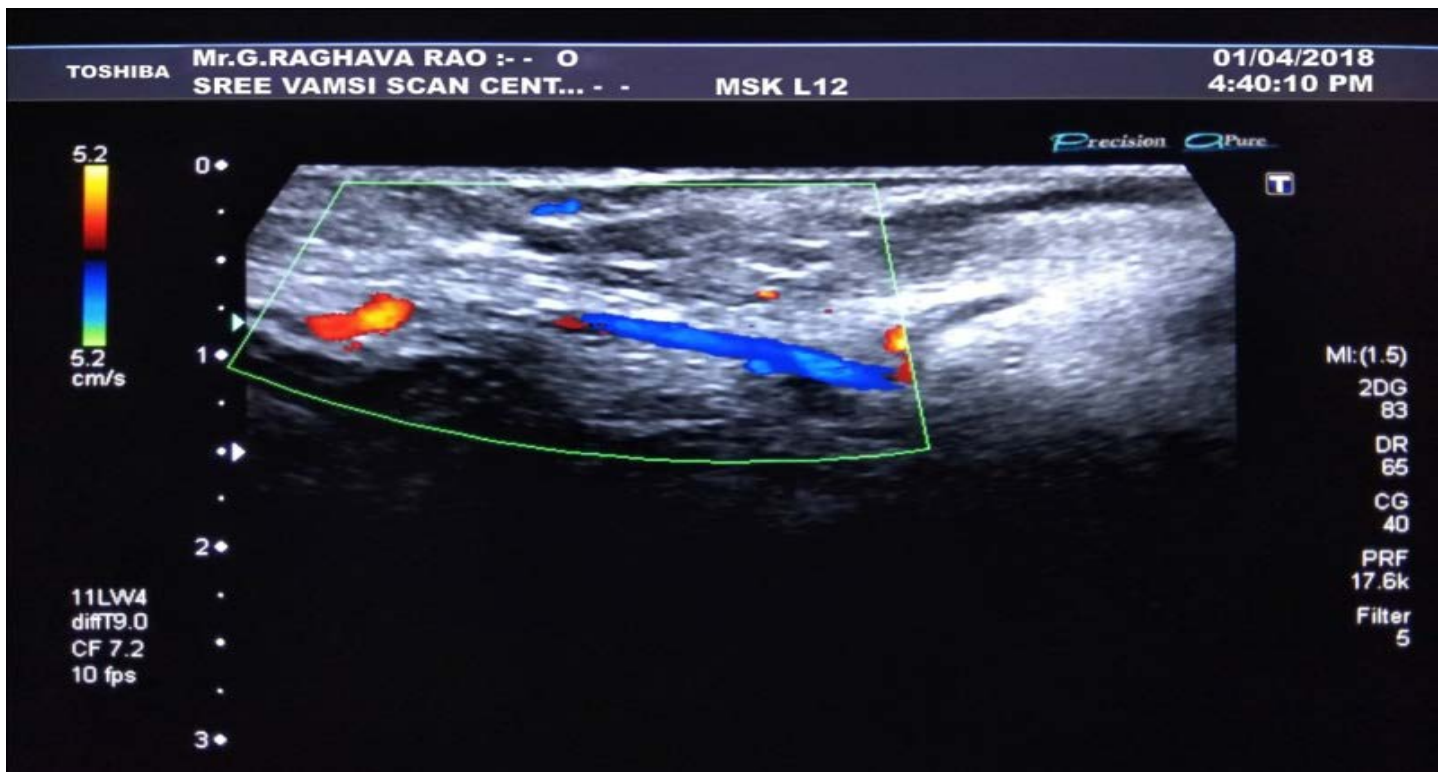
Site B ultrasound Doppler flowmetry indicating number of vascular channels and Doppler velocity at 10 days
